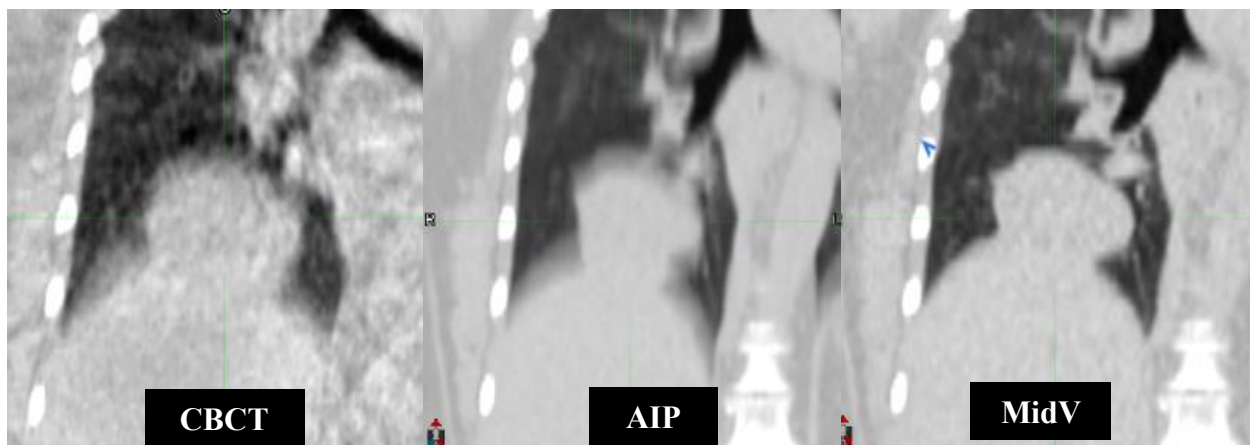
Shows the cone-beam computer tomography (CBCT), average intensity projection (AIP) reference image, and 30% phase mid-ventilation (MidV) reference image of the same tumor. AIP and MidV images are from the same slice. Magnification of all three images is consistent. Visually demonstrates blurred nature of CBCT images, blurred nature of AIP images, and sharp nature of MidV images. The AIP was registered with the CBCT, and the MidV was registered with the CBCT.
